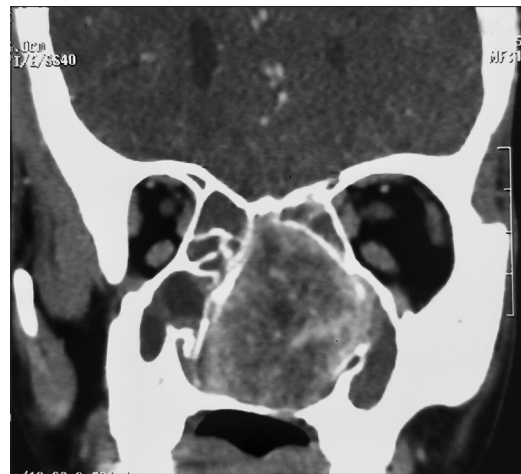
Computed tomography scan of the nose and paranasal sinus with coronal view showing a large sinonasal non-Hodgkin's lymphoma mass with bone erosion
